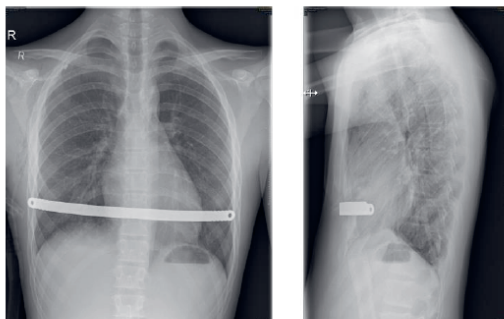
Chest X-ray showing anterior and lateral view after correction of pectus excavatum using Nuss procedure.
